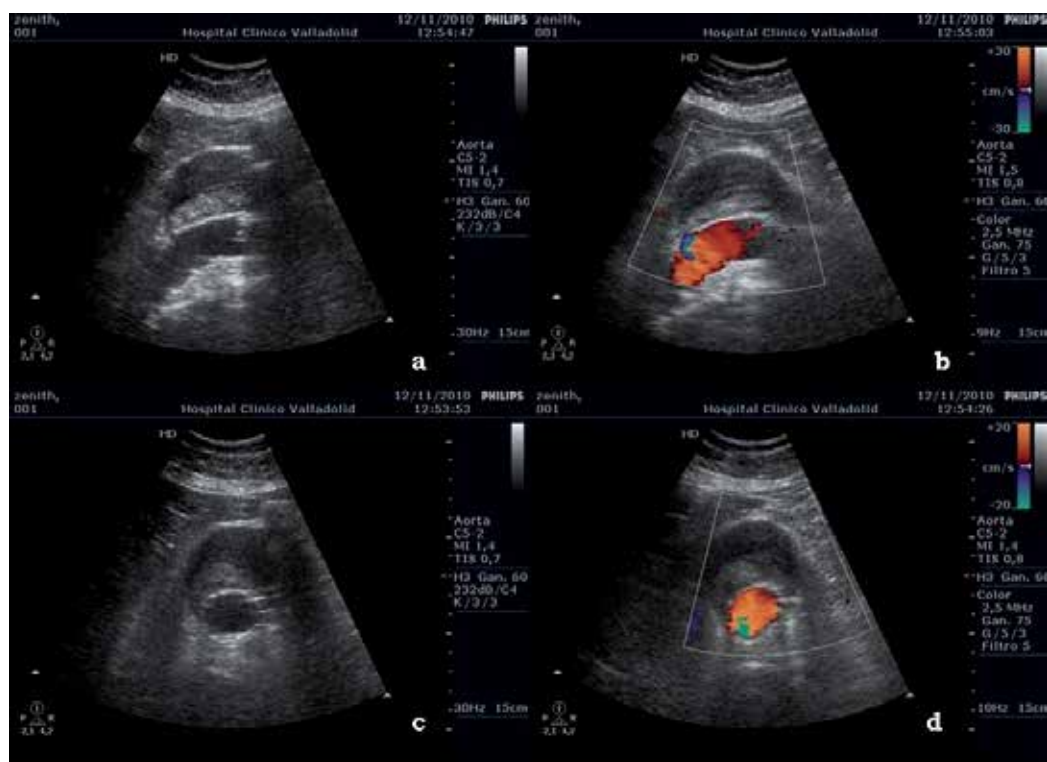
Ultrasound scan imaging, main body endograft. Longitudinal view (a,b) and cross-sectional view (c,d) with no evidence of endoleak.
